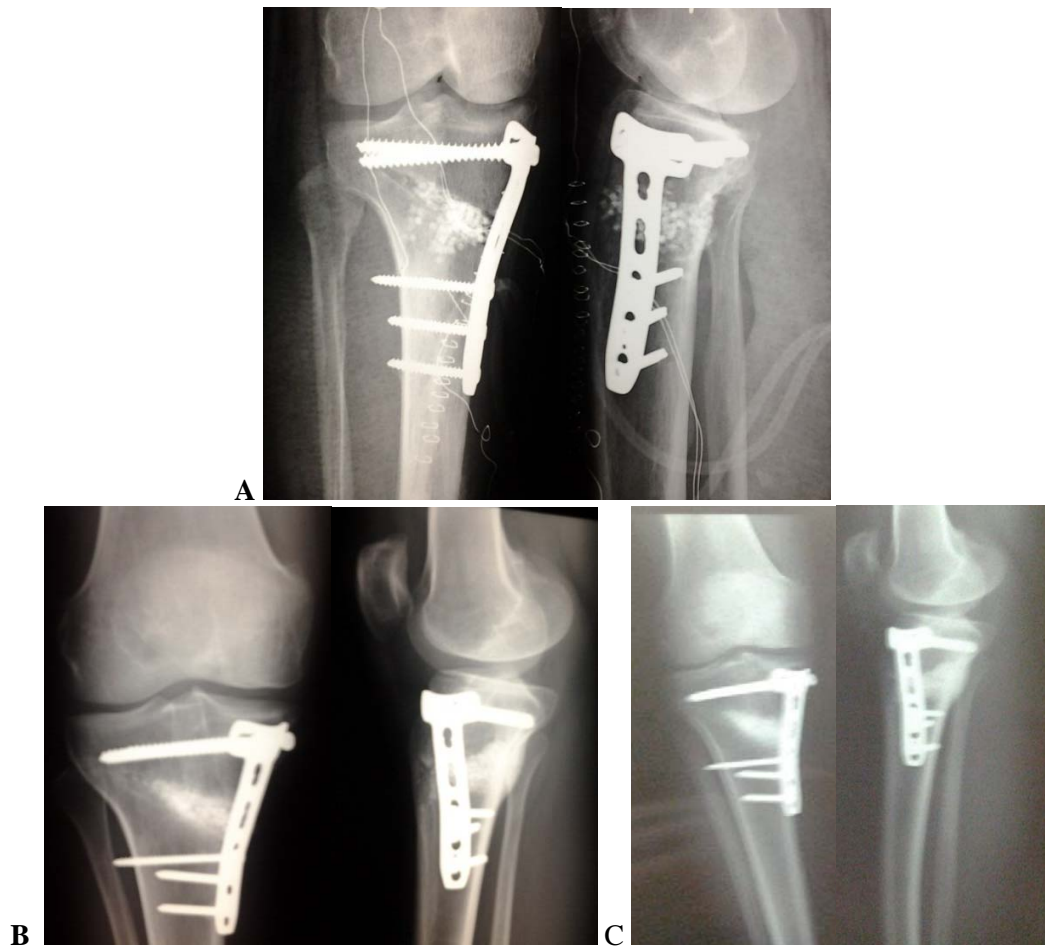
Post-operative follow-up x-rays: A, in operative day. B., after 2 months C, after 1 year.
